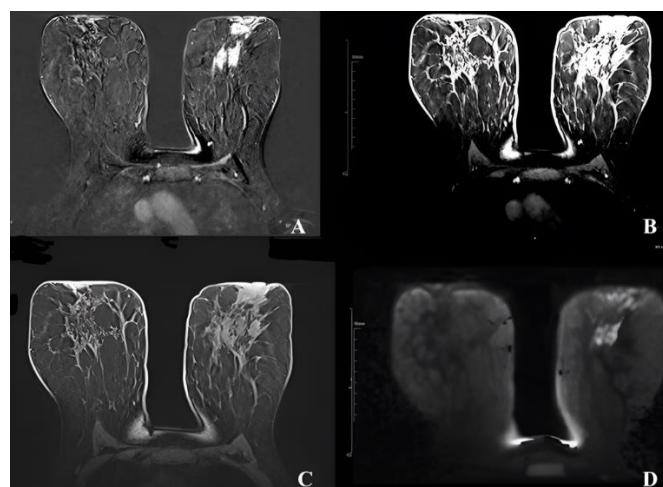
Magnetic resonance (MRI) sections of breast associated mass: A. T1-weighted dynamic contrast-enhanced, B. Contrast-enhanced T1-weighted fat-suppressed subtraction, C. T1-weighted fat-saturated pre-contrast, D. Diffusion-weighted (DWI)
